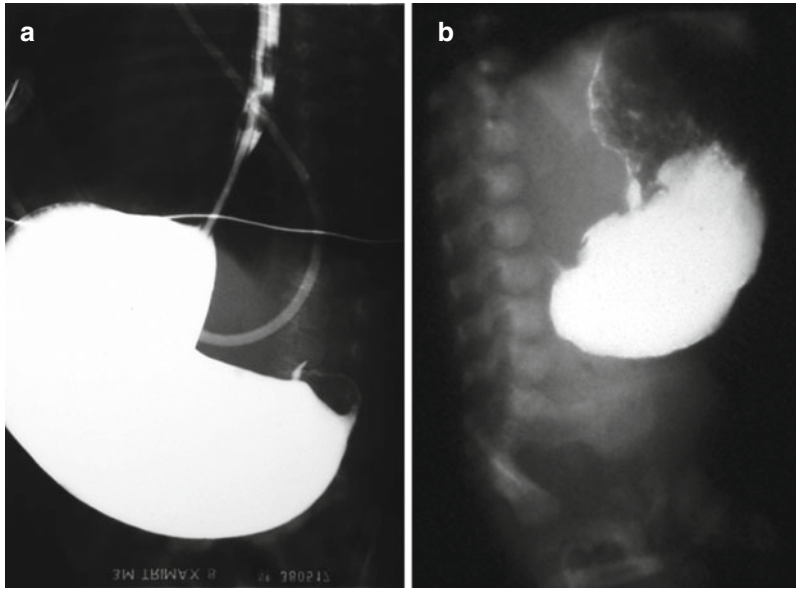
UGI tract radiographic study in newborn with HPS. (a) Oblique and (b) lateral views show a large distended stomach filled from barium and delayed gastric
